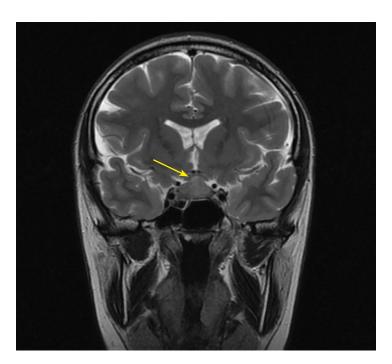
Non-contrast MRI of the head, T2 WI, coronal (frontal) projection. MR picture of an "adenoma" of the pituitary gland measuring 10×15×20 mm with suprasellar growth and moderate compression of the chiasma (changes are indicated with an arrow).
